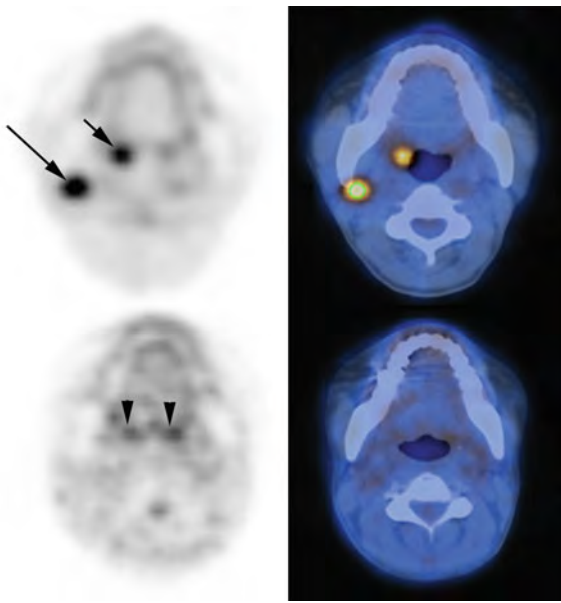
Axial FDG-PET/CT at the oropharyngeal level in a patient with a right tonsillar SCC (*short arrow*) and a 1.8 cm metastatic right level II node (*long arrow*) before treatment (*top row*) and after completion of chemoradiation (*bottom row*). Pretreatment, both tumour sites show avid FDG uptake; tonsil SUVmax = 6.1, Level II node SUVmax = 4.3. Post treatment, neither site shows appreciable increased FDG uptake. The patient has had no recurrence as of 2 years post treatment. Mild physiological FDG uptake is present in lymphoid tissue in the tongue base (*arrowheads*)
